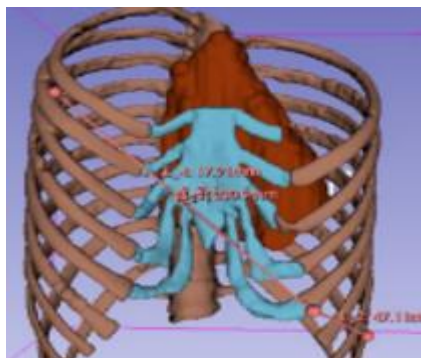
3D reconstruction of the chest wall following segmentation of previously obtained CT Figures.
